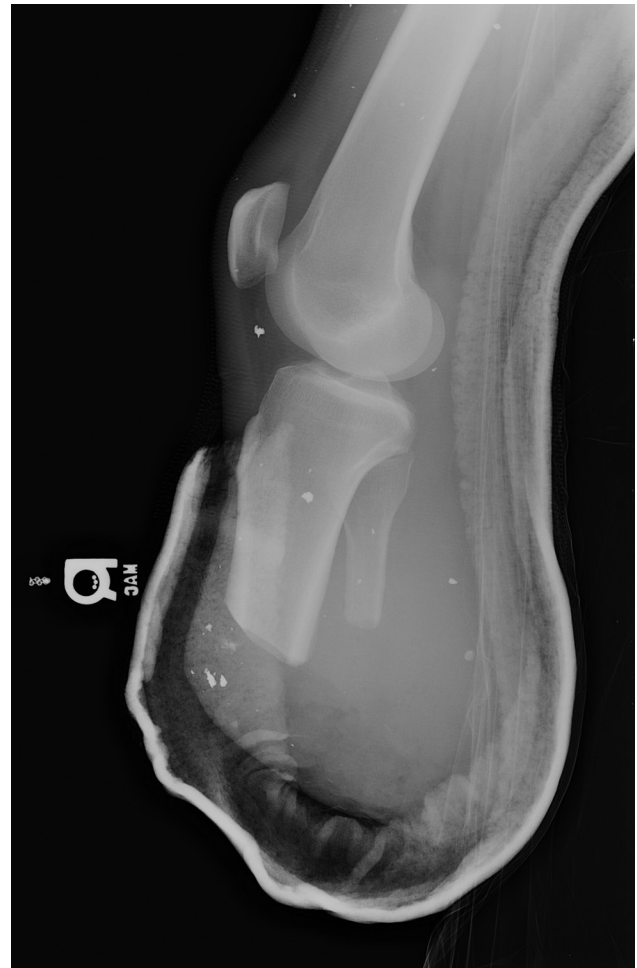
Lateral radiograph of a well-padded transtibial amputation in a posterior splint designed to prevent knee flexion contracture but avoid potential patella-related complications.
